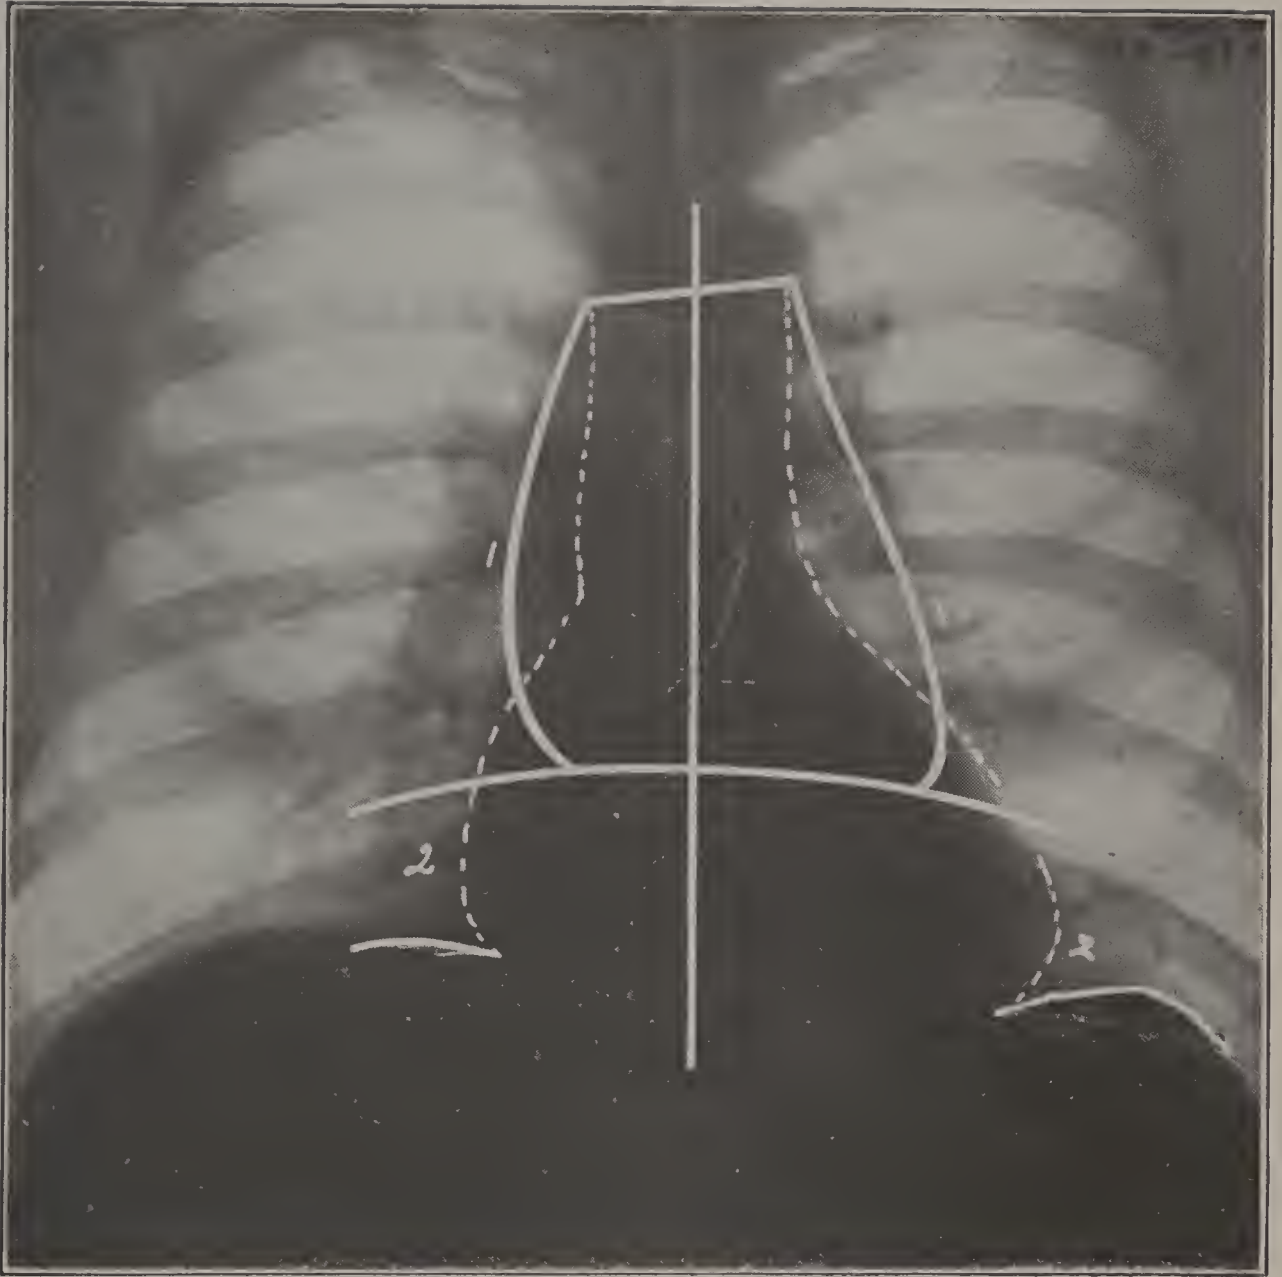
Radiographs taken during forced inspiration.
